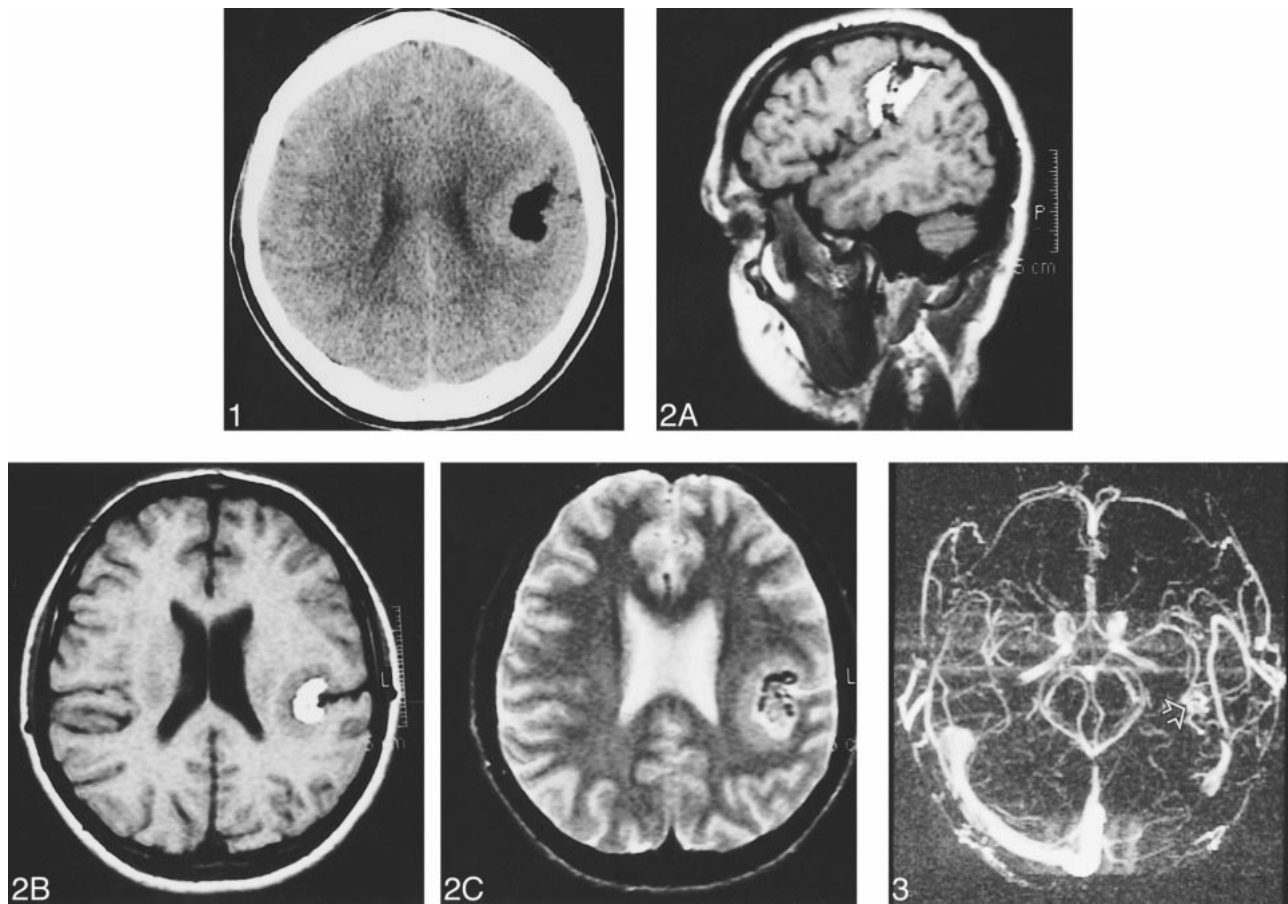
Unenhanced CT scan shows a very hypodense lesion located within a thickened layer of infolding cortex in the left hemisphere.
